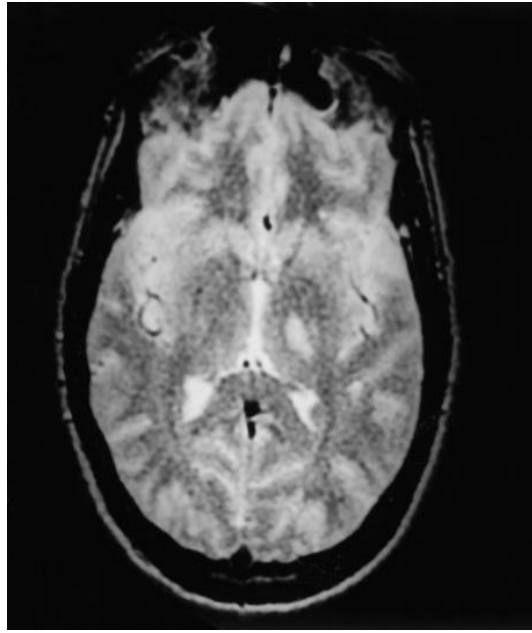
T2-weighted MRI scan showing left thalamogeniculate (inferolateral) infarction.
